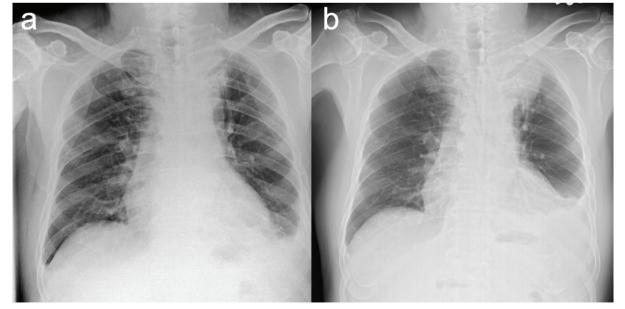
Chest X-ray performed at the emergency department (a) and 2 weeks after antibiotics treatment (b), showing an enlarging mass at the apex of the left upper lobe.
